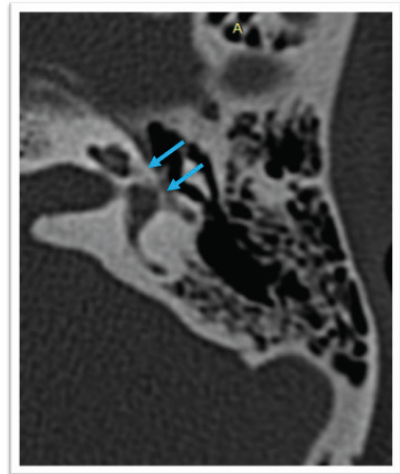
Axial CT images of the temporal bones with grade 2B otosclerosis in a 55-year-old female patient, showing a reduction in the usual bone density, which extends from the fissula ante fenestram to the middle turn of the cochlea (blue arrows).
